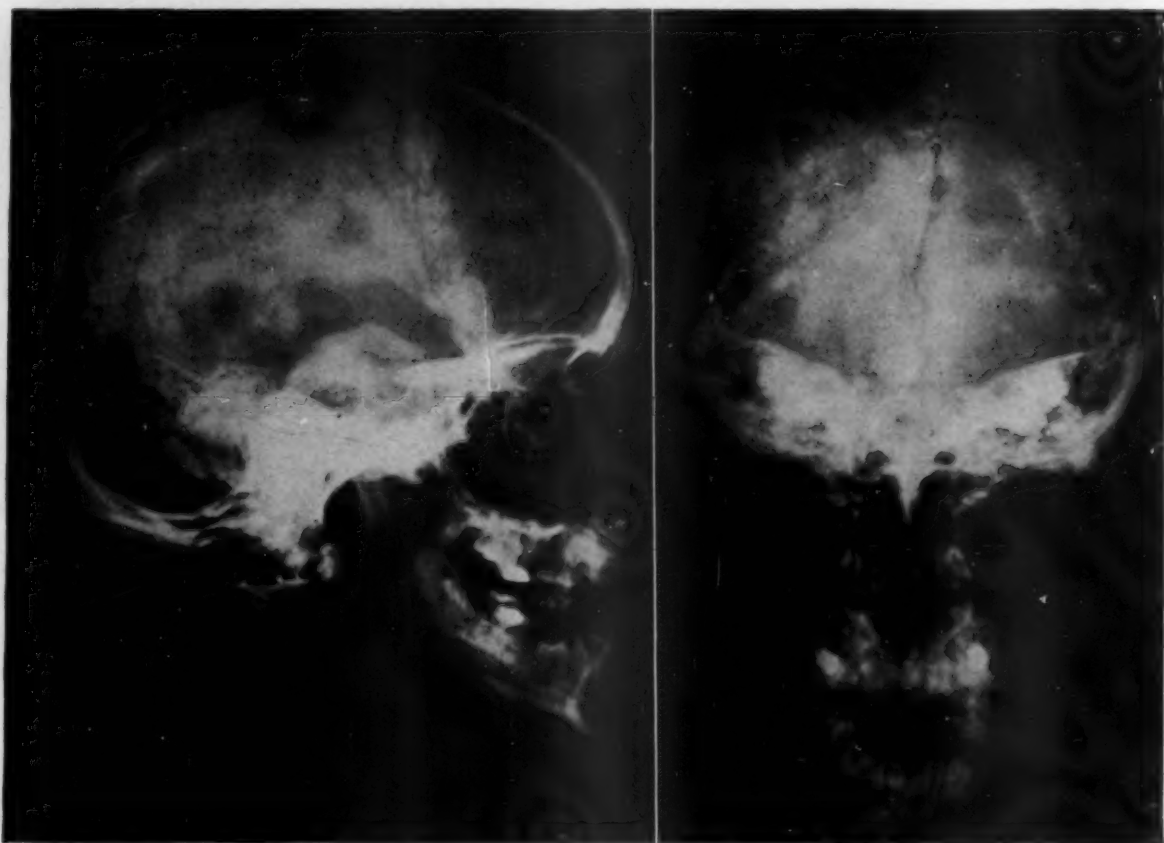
X-rays of skull showing wide open sutures, open fontanelle, and wormian bones.
